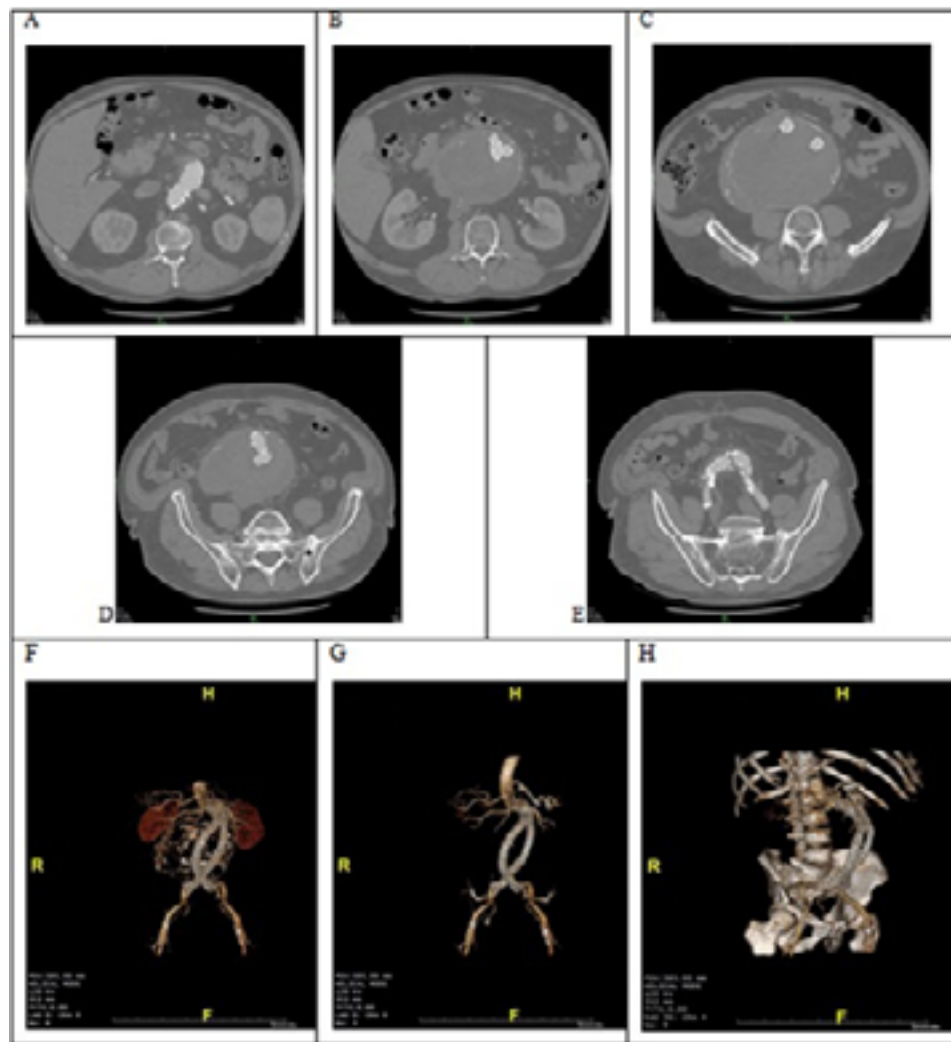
Computed tomography angiograms performed one month after the intervention. A-G) axial sections F-H) three-dimensional reconstructions.
